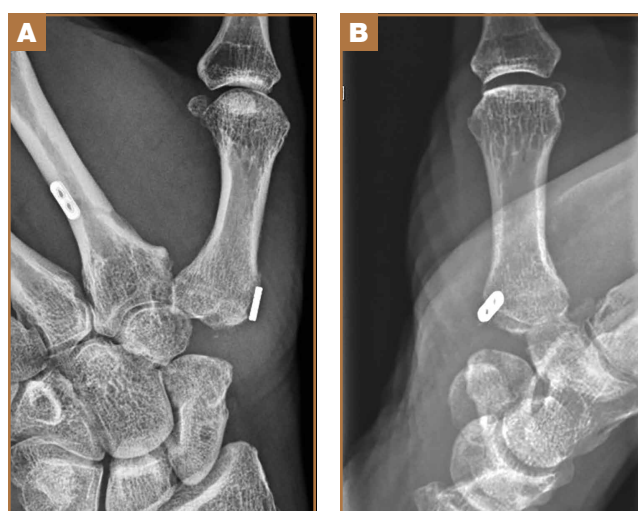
Four months after Artelon explantation, total trapeziectomy, and suture-button suspensionplasty, radiographs show good maintenance of the carpometacarpal joint space. (A) Betz view; (B) anteroposterior view.
